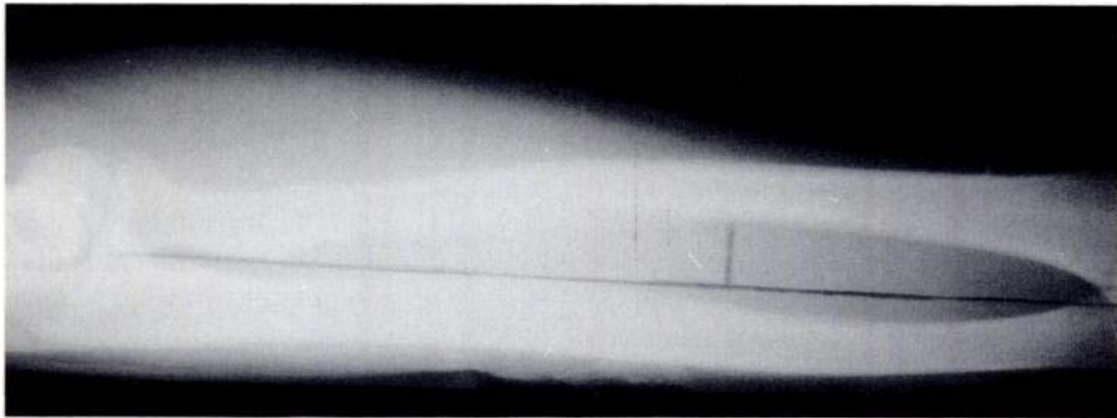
X-ray measurement of Radial bowing
